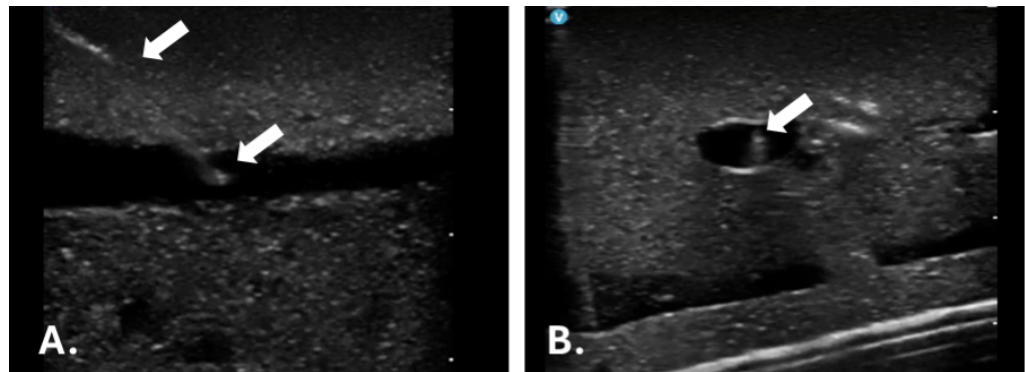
Ultrasound training in In-plane and Out-of-plane needle positioning and visualisation— images from the gel training model
